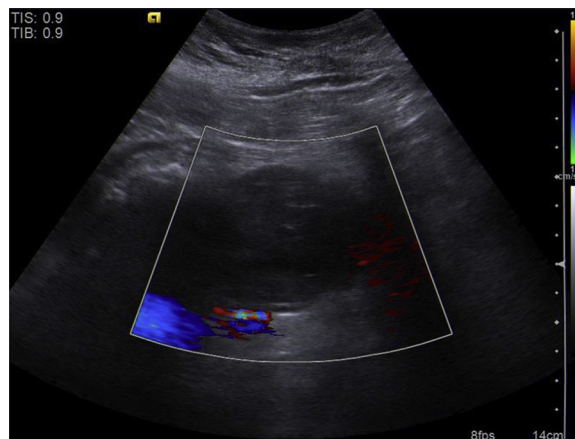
Ultrasound image showing absence of Doppler flow in the thrombosed aneurysm sac 3 days after thrombin injection.
